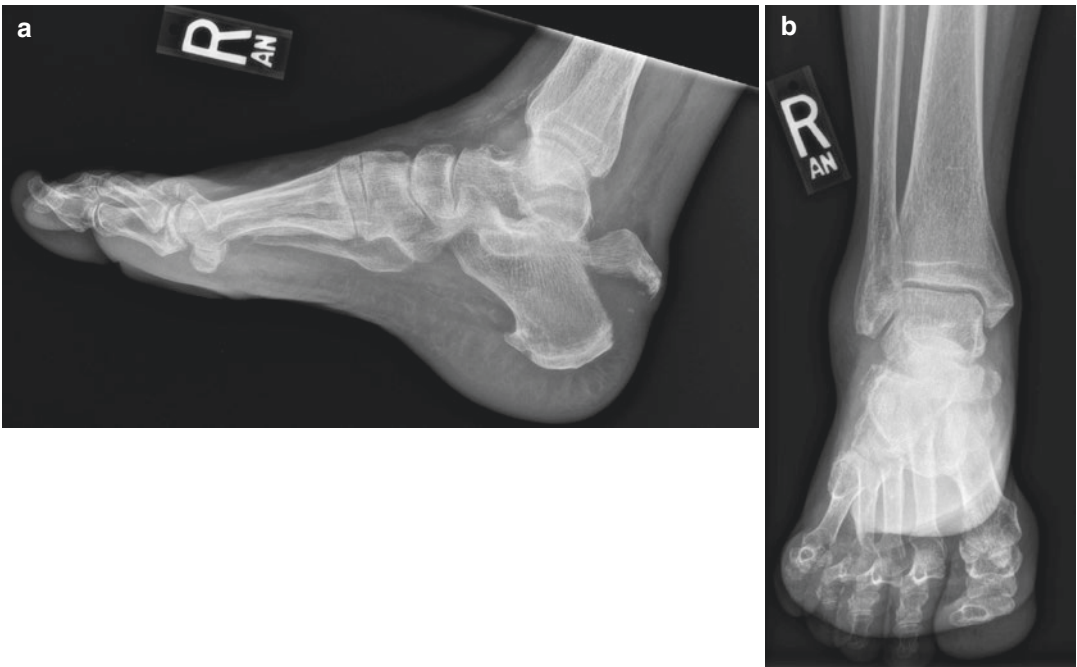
(a) AP and (b) lateral radiographs of the foot and ankle
